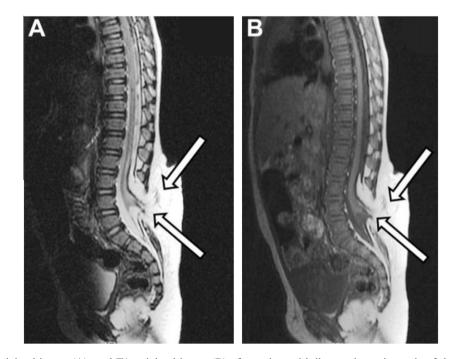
MRI, T2-weighted image (A), and T1-weighted image (B) of a patient with lipomyelomeningocele of the lower lumbar region, showing a low-lying cord at the level of L3-L4 with spina bifida involving lower lumbar and sacral spine. Note intra- and extra-spinal lipoma (arrow).
